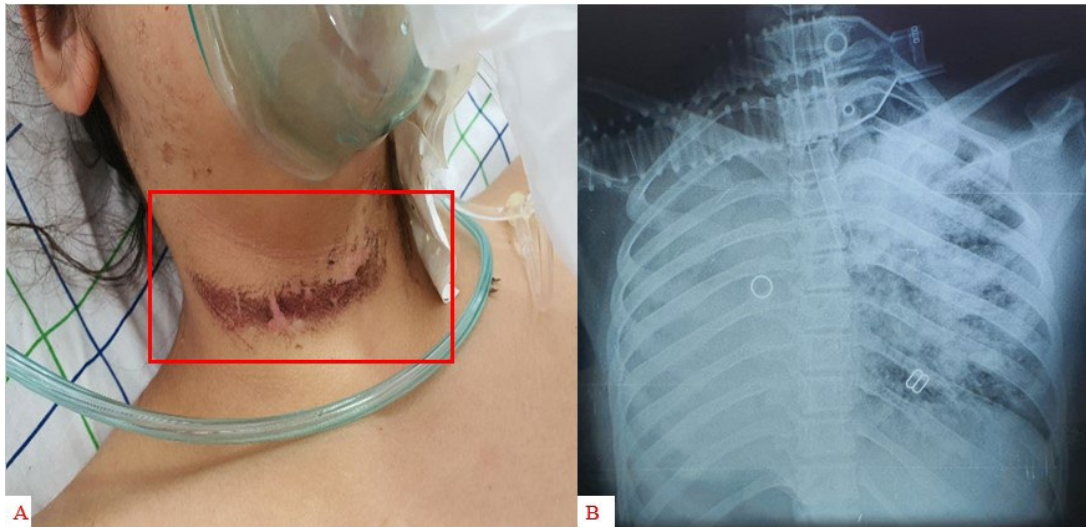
clinical constat and results of Chest X-ray
